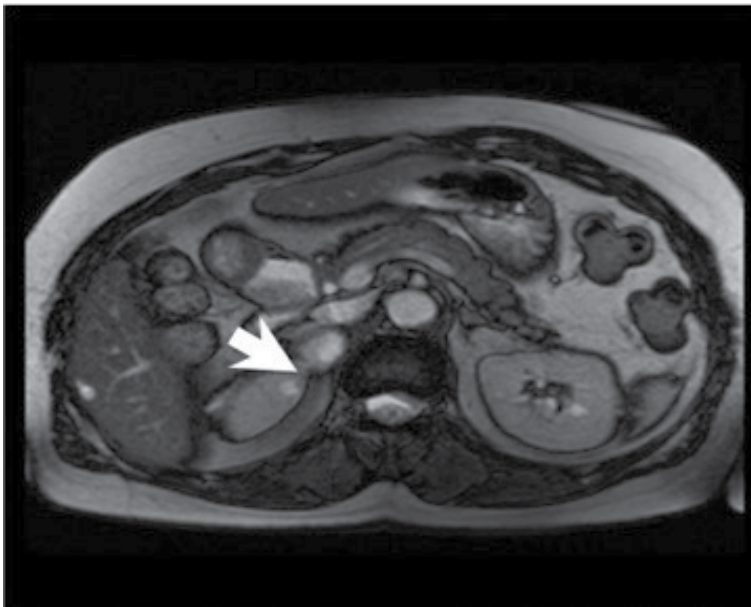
Axial MRI showing a mass (*white arrow*) in the medial limb of the right adrenal gland with a heterogeneously high signal on T2-weighted imaging consistent for a pheochromocytoma.
